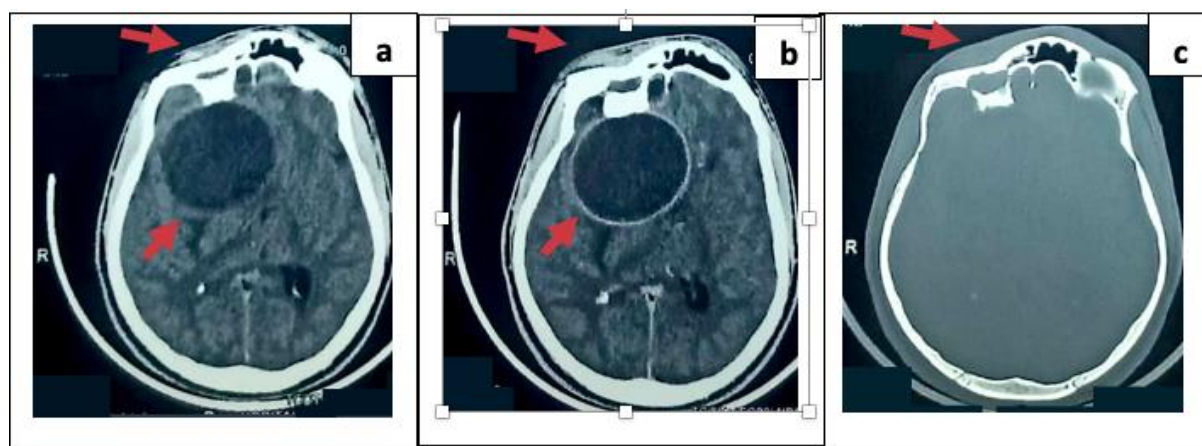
Cranioencephalic CT scan of a patient admitted complication stage (brain abscess). (a) axial section without contrast product injection showing a roundel image in the right frontal which is enhanced after injection of contrast product (b) and which is opposite a right frontal sinus fracture with intraparenchymal bone fragment (c).
